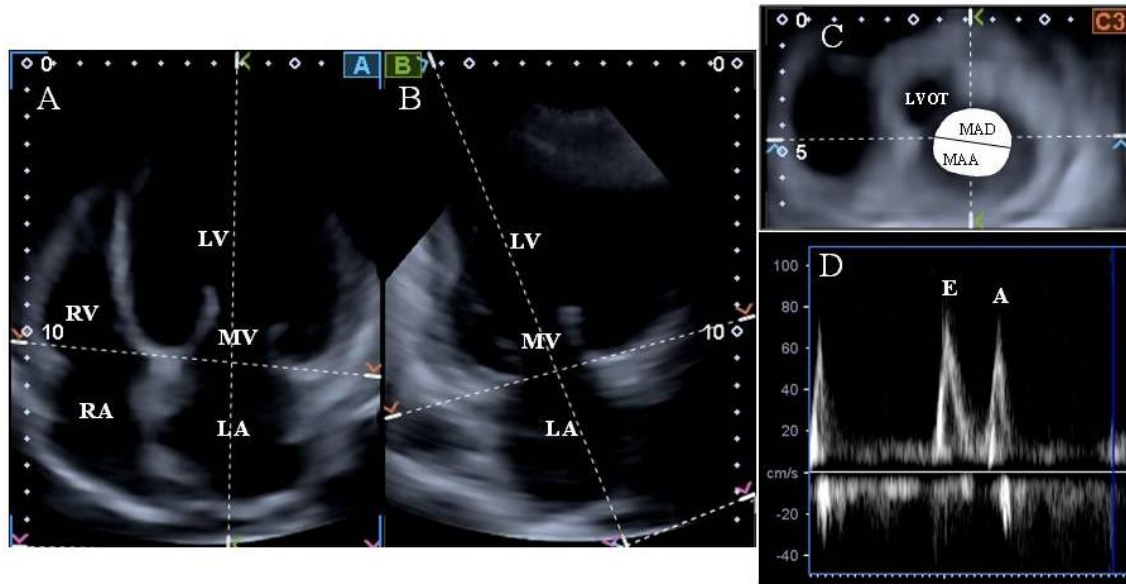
From 3D echocardiographic dataset, the mitral annulus (MA) could be obtained by optimizing cross-sectional planes on the apical 4-chamber (A) and 2-chamber (B) views and therefore demonstrating the optimal MA image (C). Using Doppler-derived mitral inflow peak A wave velocity, the left atrial ejection force (LA-EFO), a characteristic of left atrial systolic function, were calculated.
